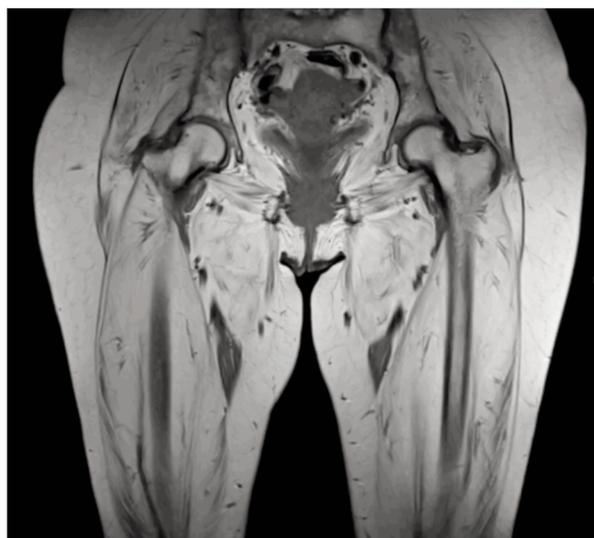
Coronal T1-weighted image showing diffuse advanced fatty infiltration of both thigh and pelvic muscles bilaterally and near complete replacement by fat of the quadriceps muscles bilaterally
